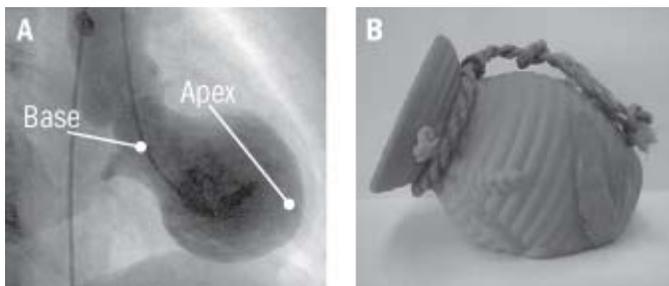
(A) X-ray of left ventricle showing apical ballooning (B) a Japanese pot used to trap octopus (Prasad, 2007)
